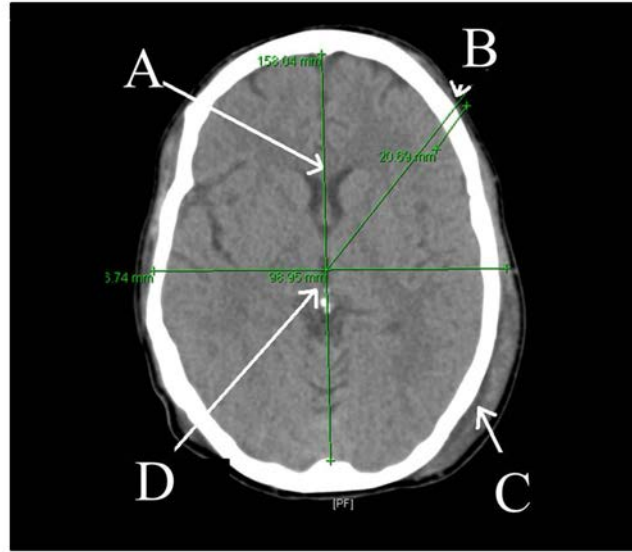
Example CT of a subject with a TBI used to calculate ideal monitoring depth in TBI patients. A Corpus Callosum, B Contact Point to start measurement, C Haematoma and D Third Ventricle (axis origin).
